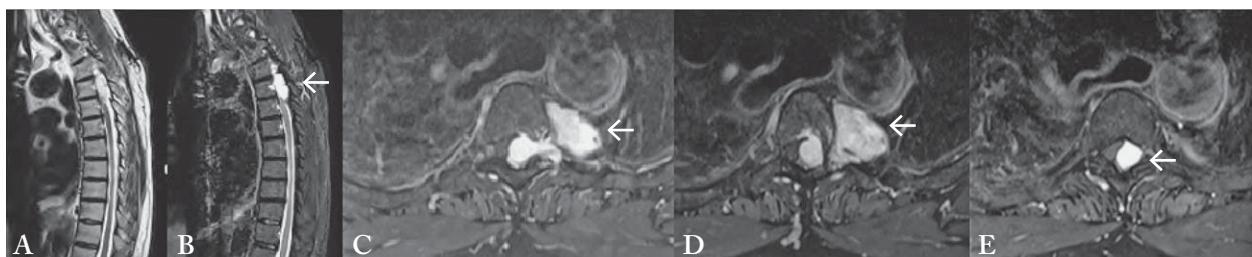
MRI of the thoracic spine: (A) T2-weighted sagittal sequence showing the intraspinal tumor T3-5 with hyperintense signal (arrow); (B) post-contrast T1-weighted sagittal sequences showed homogeneous enhancement of the tumor; (C, D, E) post-contrast T1-weighted axial sequences revealing dumbbell-shaped tumor with lobular contour extending intraspinally with displacement of the spinal cord to the right and growth through the intervertebral foramen of T4 into the left middle thorax.
